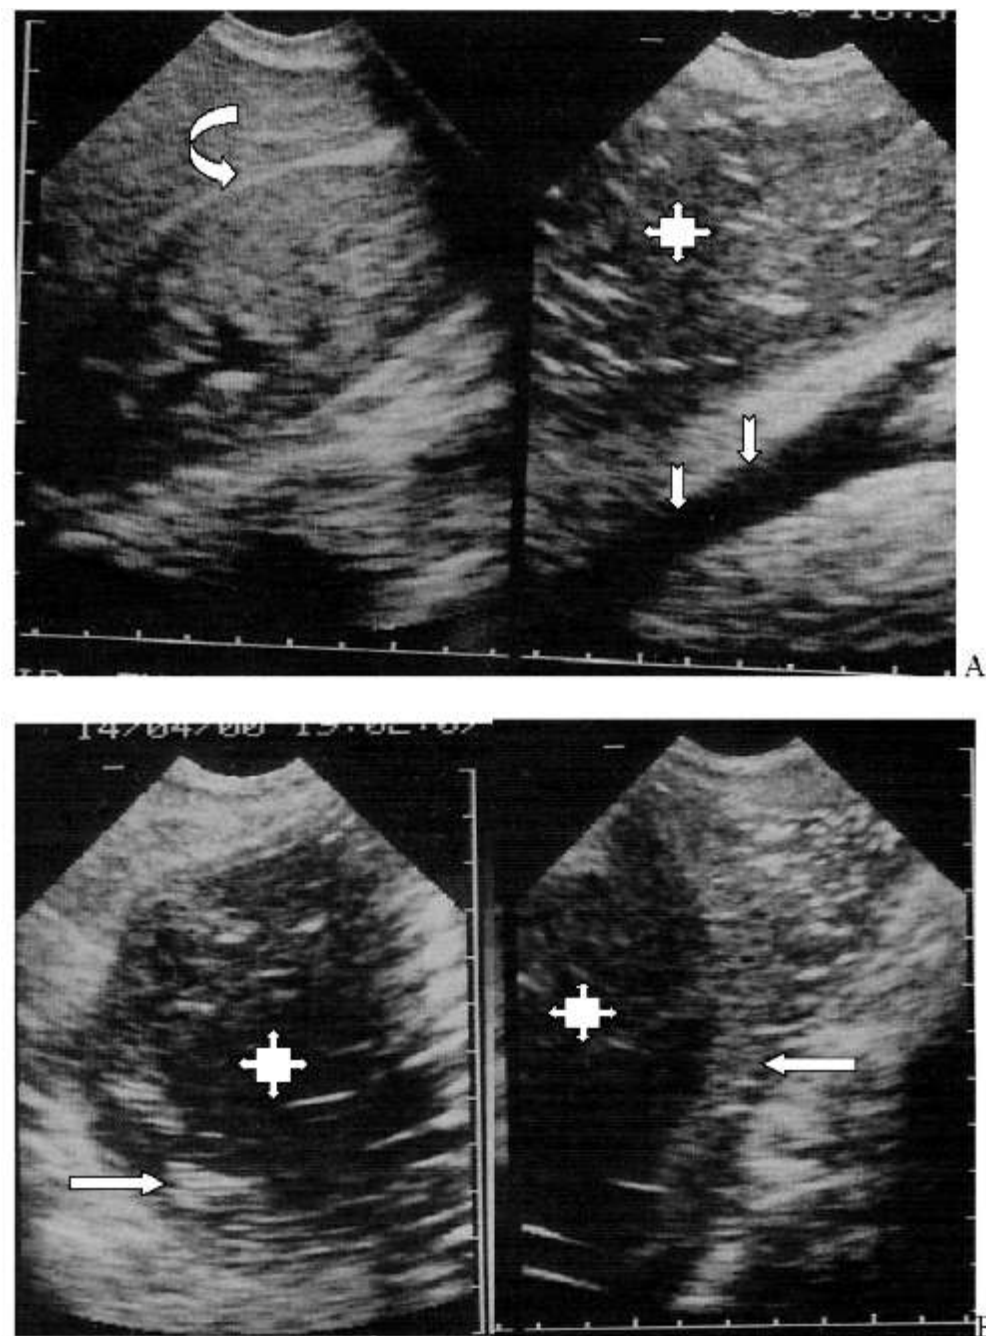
Ultrasound images of the patient showing a well circumscribed thick-walled abscess (quad arrow). Note the internal echoes and some highly reflective specks (gas) within it. (A) Demonstrates free hepatorenal space (curved arrow), the anterior location of the abscess to the abdominal aorta (notched arrows) and its extension beyond the bifurcation of the aorta into the pelvis while (B) Focuses on the thick wall of the abscess (open arrow).
